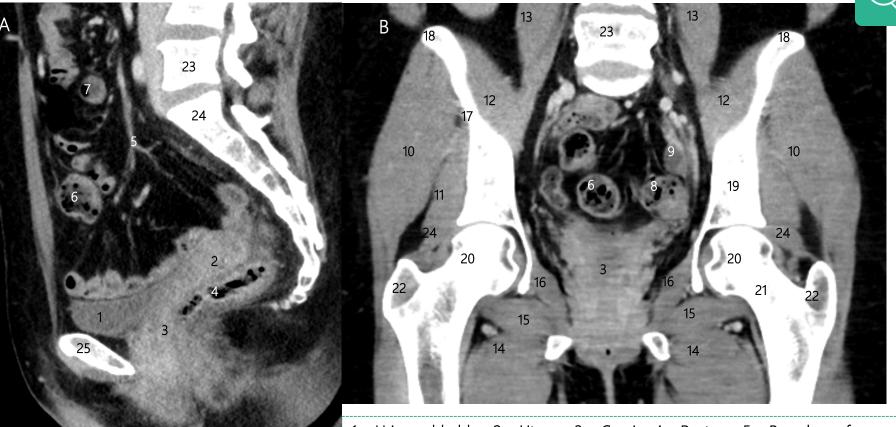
Cross sectional anatomy of the female pelvis. Sagittal (A) and coronal (B) reformatted CT images of the pelvic organs.
